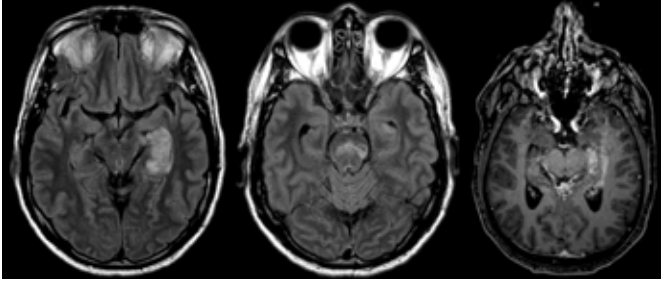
Cranial magnetic resonance imaging. (A) Axial FLAIR, showing vasogenic edema and tumefactive effect involving the left hippocampal formation; (B) Axial FLAIR, demonstrating signal alteration in the pons, bilaterally transversely (band-like), with cavitations, suggestive of a sequela; (C) Axial post-contrast T1, highlighting leptomeningeal and cortical enhancement of the hippocampal formation and contiguous enhancement of the left choroid plexus.
